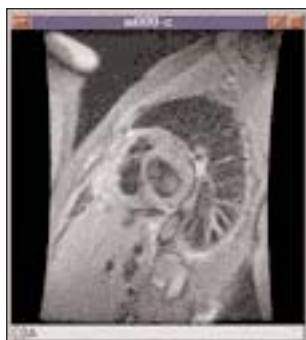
One of the MRI images of the left ventricle displayed on the Icon workstation (Courtesy of Universitas Hospital).
